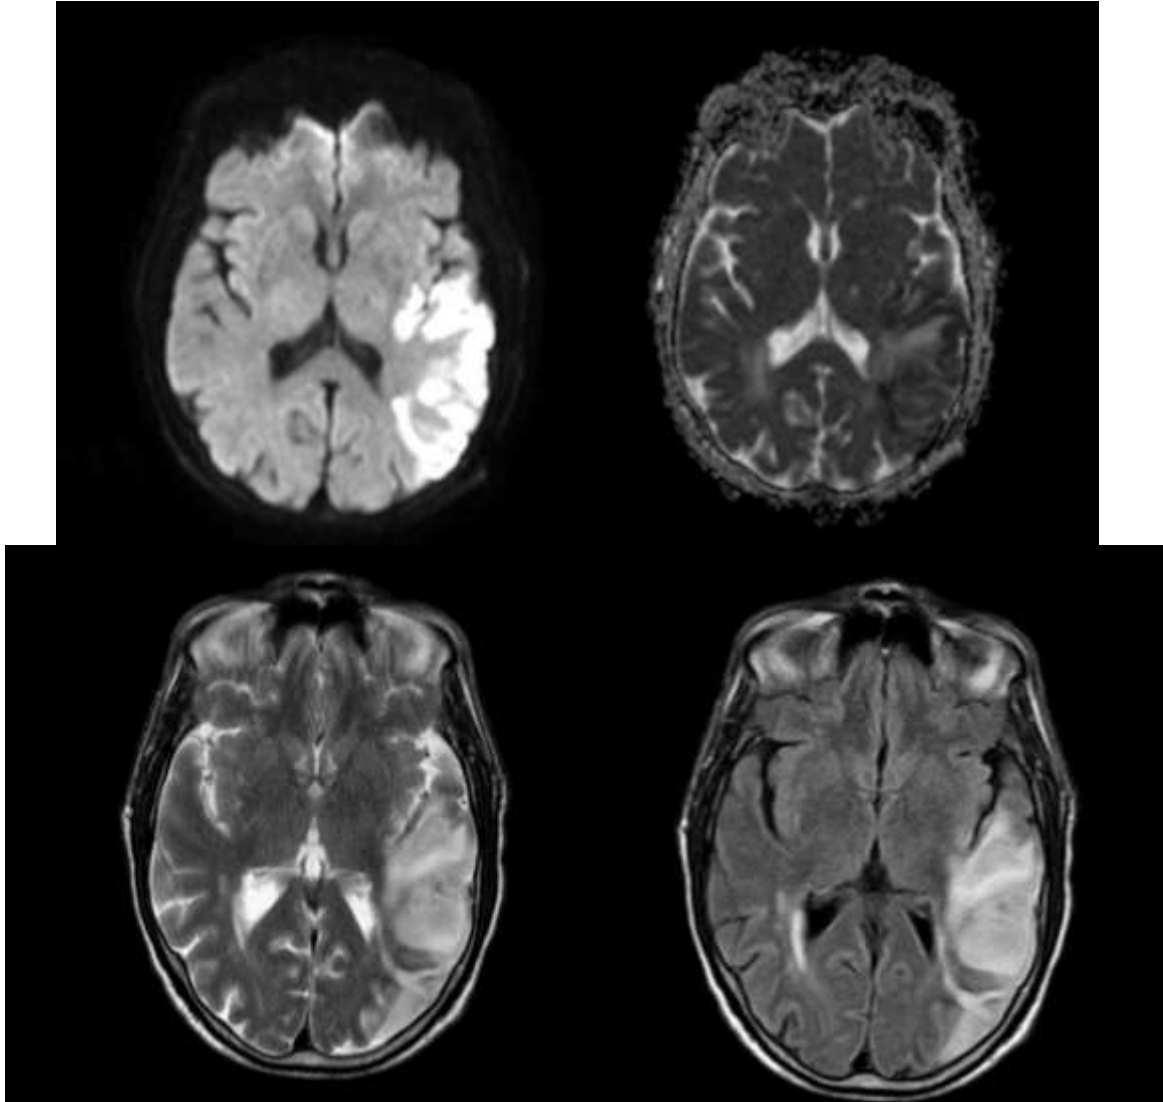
MRI brain of 60 year old patient, diffusion restriction seen as high signal intensity on DWI(a) and signal drop on subsequent ADC(b) sequences. Hyperintensity in left parieto-occipital region seen on T2 (c) and FLAIR(d) sequences, finding consistent with acute infarct involving the left MCA territory.
